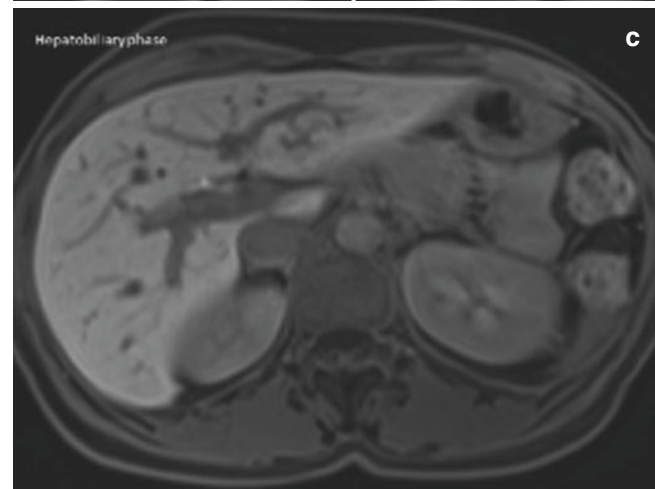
A 50-year-old female with focal nodular hyperplasia at S2 of liver underwent Gd-EOB-DTPA-enhanced MR imaging. (a) The tumor shows mild hyperintense with bright signal central scar on T2WI. (b) The tumor is hypointense on precontrast T1W imaging, heterogenous and hypervascular on arterial phase, homogenous enhancement on late phase images. (c) The tumor features hyperintense with dark central scar on hepatobiliary phase
